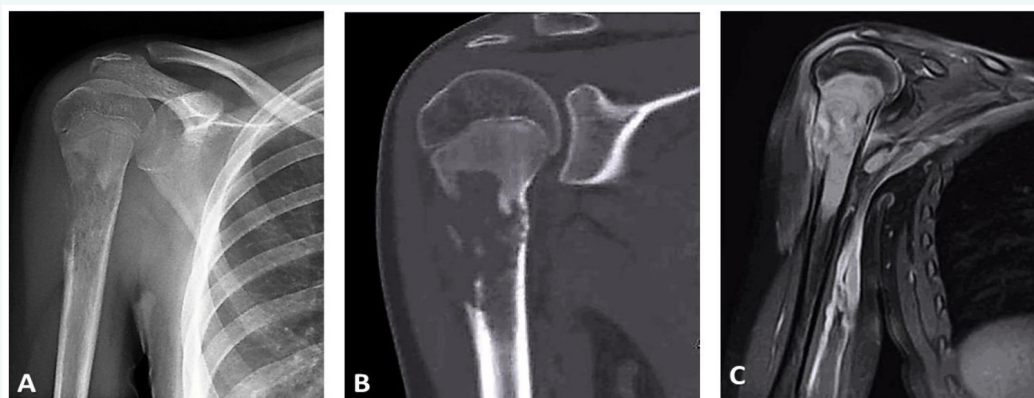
Radiographic findings of the tumor
